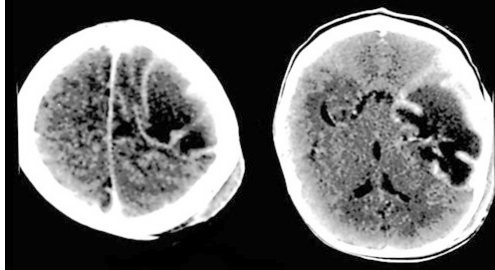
Computed tomography scan of the brain of an infant with CNS HSVI
